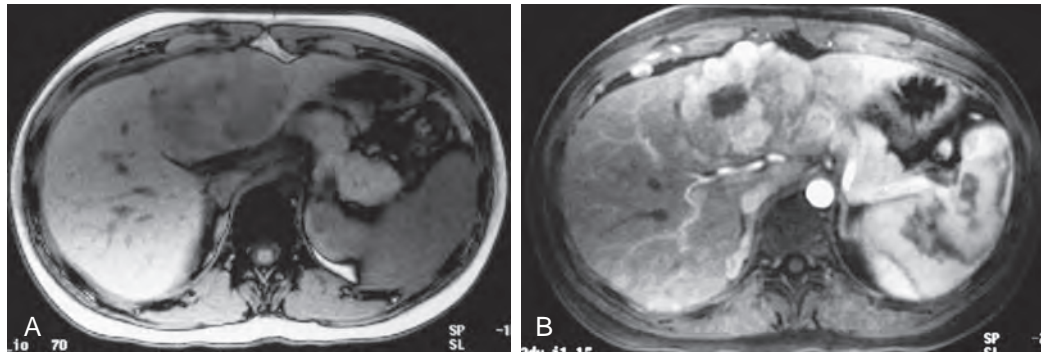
FLC: MRI findings. Unenhanced scan of a low signal intensity mass (A) that showed striking enhancement with the exception of the central scar on the contrast-enhanced image (B).
